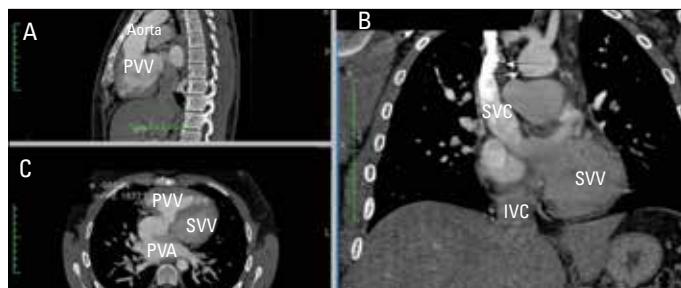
Contrast enhanced computed tomography. A) sagittal axis section shows that aorta originates from the right ventricle (pulmonary venous ventricle). B) coronal axis section shows the baffle connecting inferior and superior vena cava to the left ventricle via mitral valve. C) transverse axis section the baffle connecting pulmonary venous atria to the left ventricle via tricuspid valve
